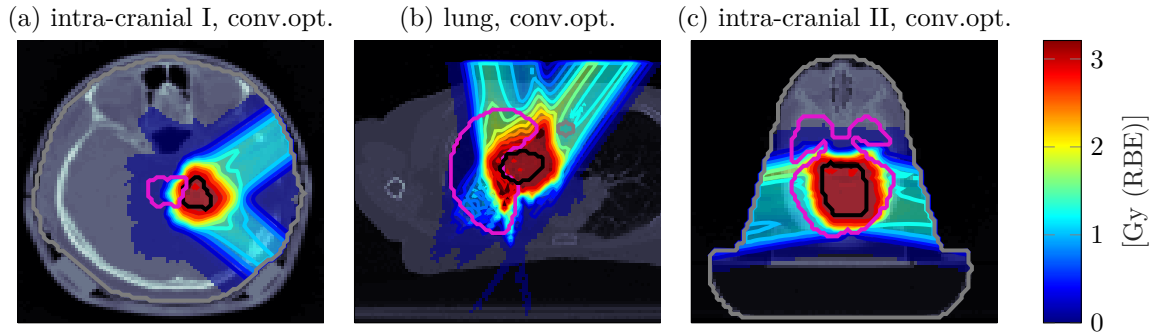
Three-dimensional intensity-modulated proton treatment plans with two angular incident beams in (a) and (b) and an almost opposing beam configuration in (c). conv.opt indicates conventional optimization and hence does not explicitly account for setup and range uncertainties during optimization. Each panel shows the transversal iso-center slice of the CT scan overlaid by transparent dose colorwash and solid isodose lines. The solid black contour represents the CTV and the solid pink contour the corresponding critical organ at risk.
